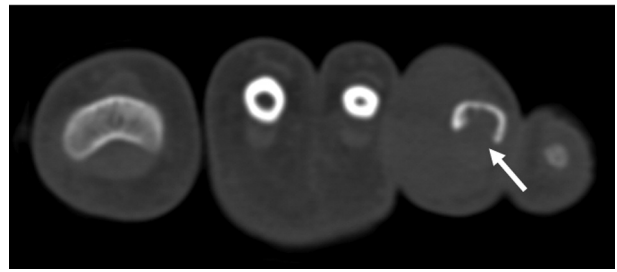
Axial computed tomography scan reveals an iso-attenuated mass with plantar cortical destruction (arrow) in the left fourth toe. The different toes are intact.
